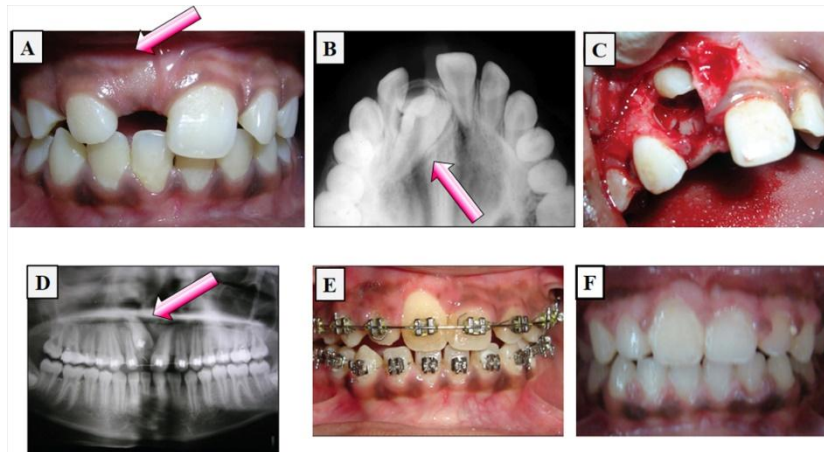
A-F: Trauma-induced dilaceration, positional alteration, and impaction of a permanent maxillary anterior tooth following trauma to the primary anterior teeth: clinical, radiographic, intraoperative, and therapeutic follow-up.
